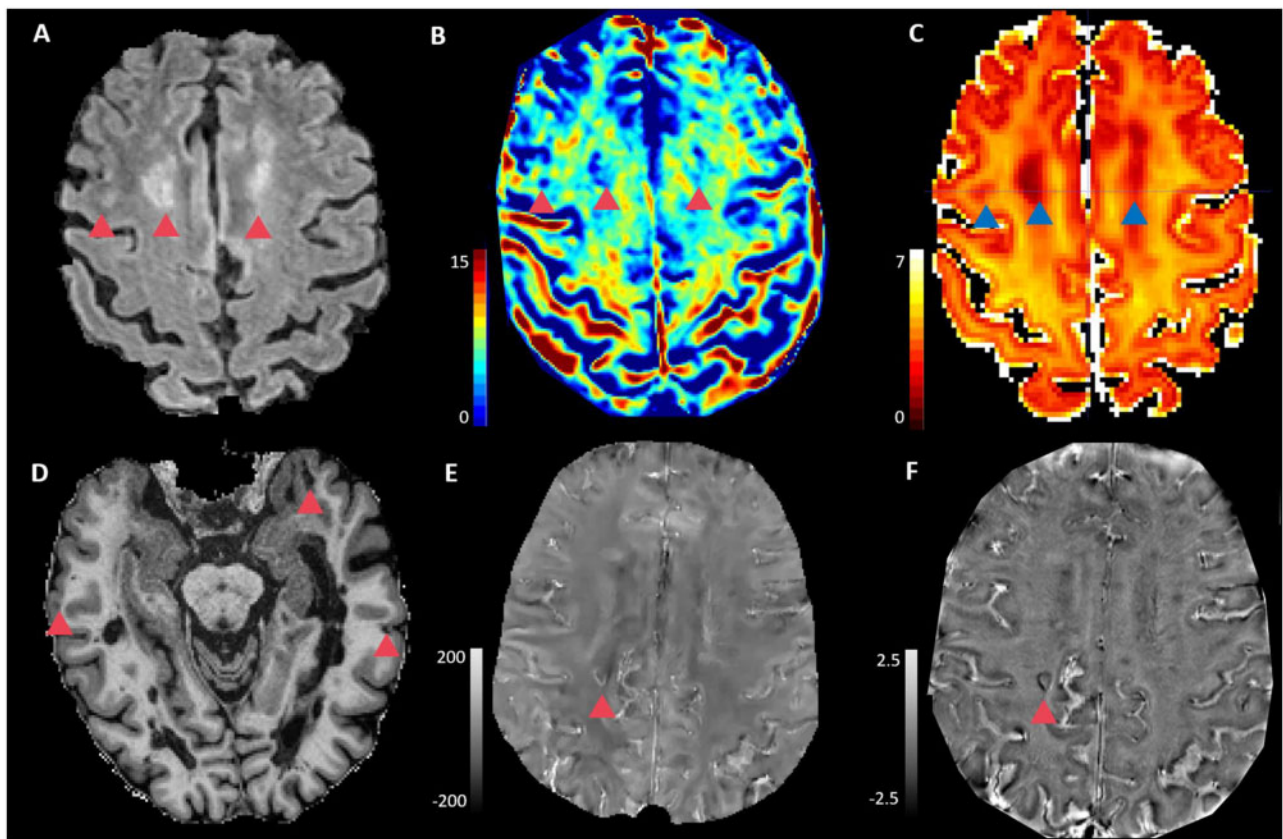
Axial images in one exemplary multiple sclerosis patient. (A) FLAIR, (B) MWF map, (C) NODDI-NDI map, (D) MP2RAGE, (E) 3D-EPI QSM and (F) 3D-EPI unwrapped phase. Red/Blue triangles show white matter lesions (A–C), cortical lesions (D) and lesions with paramagnetic rim (E and F).
